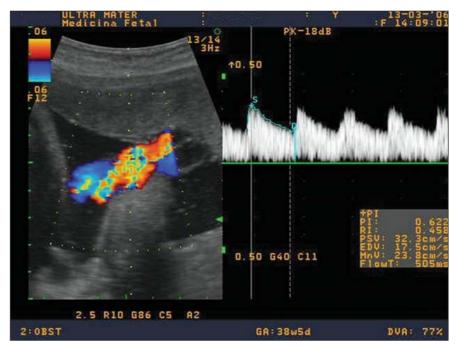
Doppler velocimetry of the umbilical artery close to the placental insertion.
